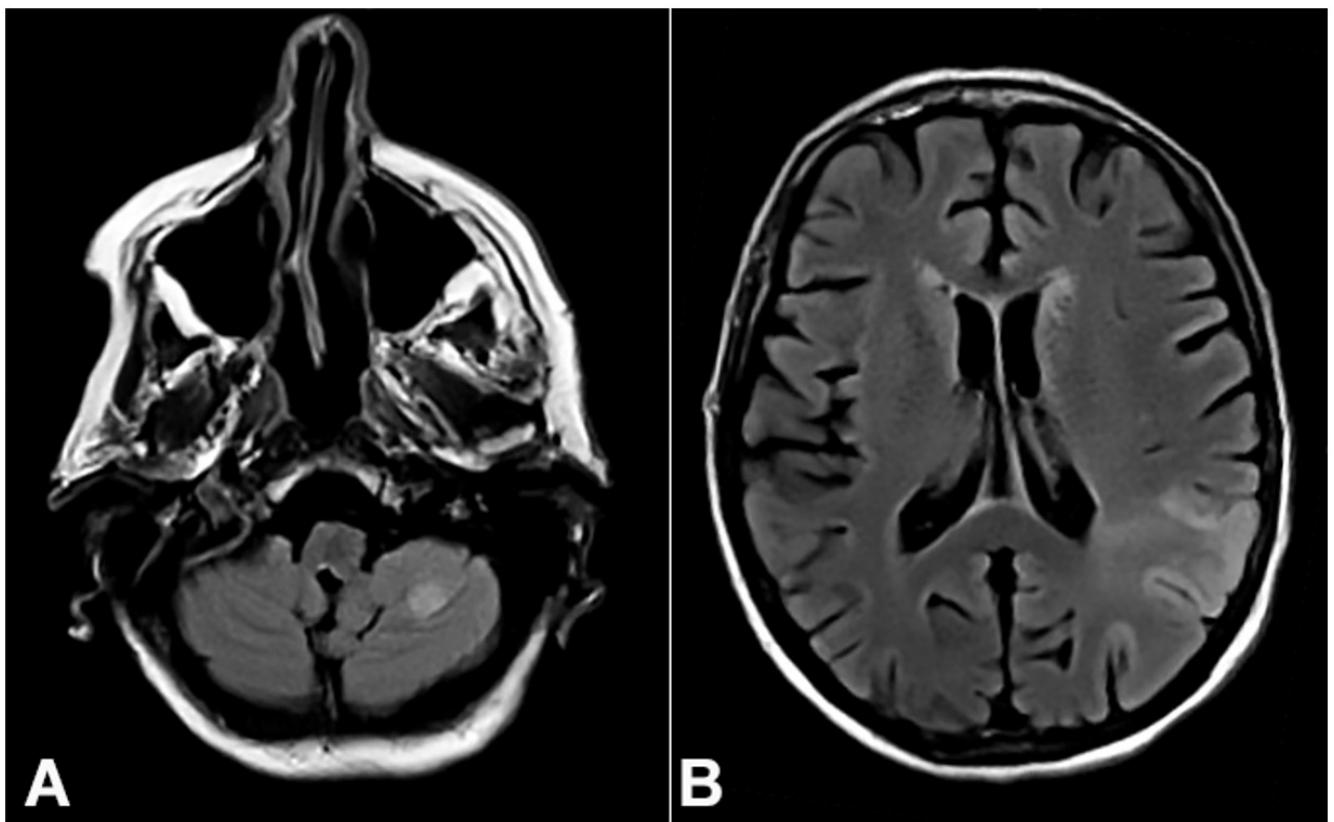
FLAIR MRI section showing in A - strokes in the left cerebellar; and in B - left parietal (B) regions of the brain, concerning an embolic etiology. (FLAIR: Fluid Attenuated Inverse Recovery; MRI: Magnetic Resonance Imaging).
